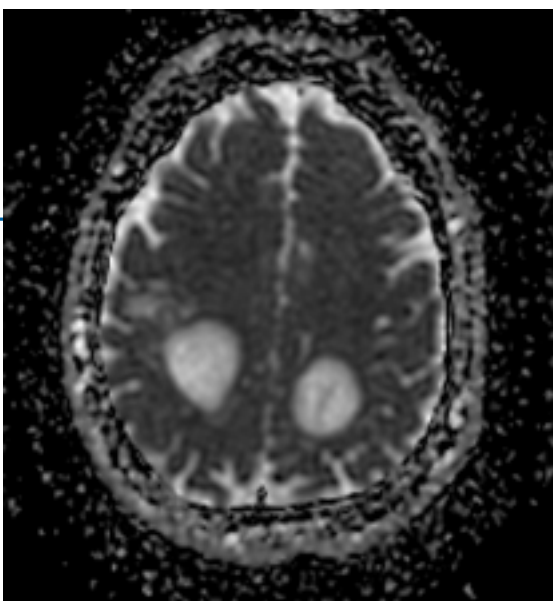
MRI images in DWI showing restricted diffusivity at the edges of the lesions prior to treatment
